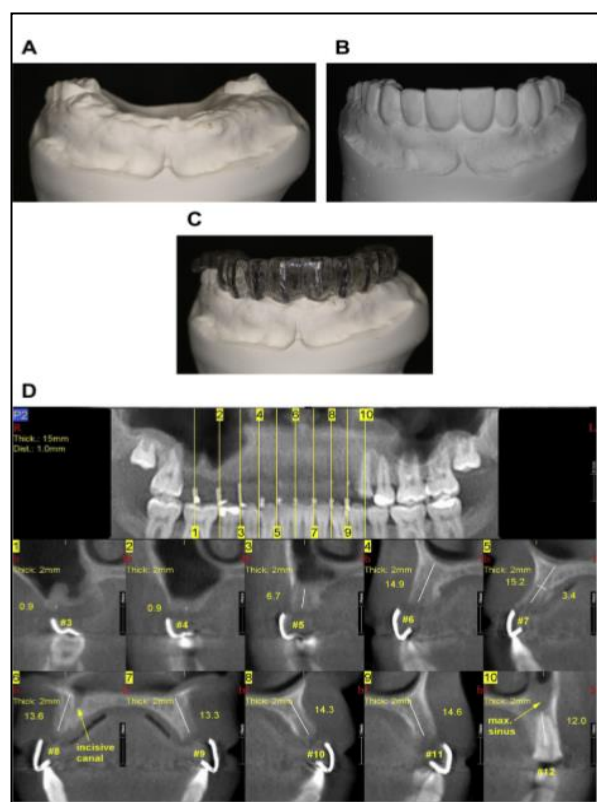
Use of a thermoplastic shim incorporating radiographic markers(A) Cast revealing missing anterior teeth. (B) The completed diagnostic waxing is duplicated in dental stone. (C) Lead foil strips applied to the stone cast are integrated into a thermoplastic stent. (D) The resulting CBCT image revealing the location of the planned prostheses and existing bone. [Image taken from Dent Clin N Am 58 (2014) 181–192]
